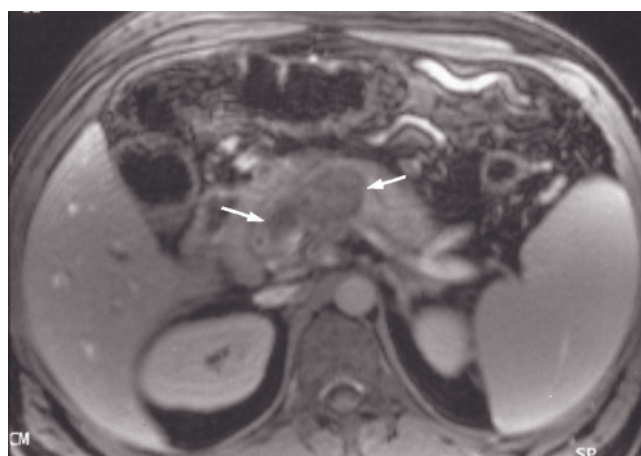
Pancreatic cancer arising in the neck. Coronal (a) and transverse (b) T2-weighted SS-ETSE, T1-weighted SGE (c), T1-weighted fat-suppressed SGE (d), and immediate (e) and 45-s (f) postgadolinium T1-weighted SGE images in a patient with a pancreatic adenocarcinoma arising in the neck of the pancreas. There is a heterogeneous mass in the pancreatic neck (arrow, a, b), which contains a cystic component. The body and tail of the pancreas are atrophic with dilatation of the main pancreatic duct. The biliary tree is markedly dilated (a). Note diminished enhancement of the solid component of the mass (e, f).
